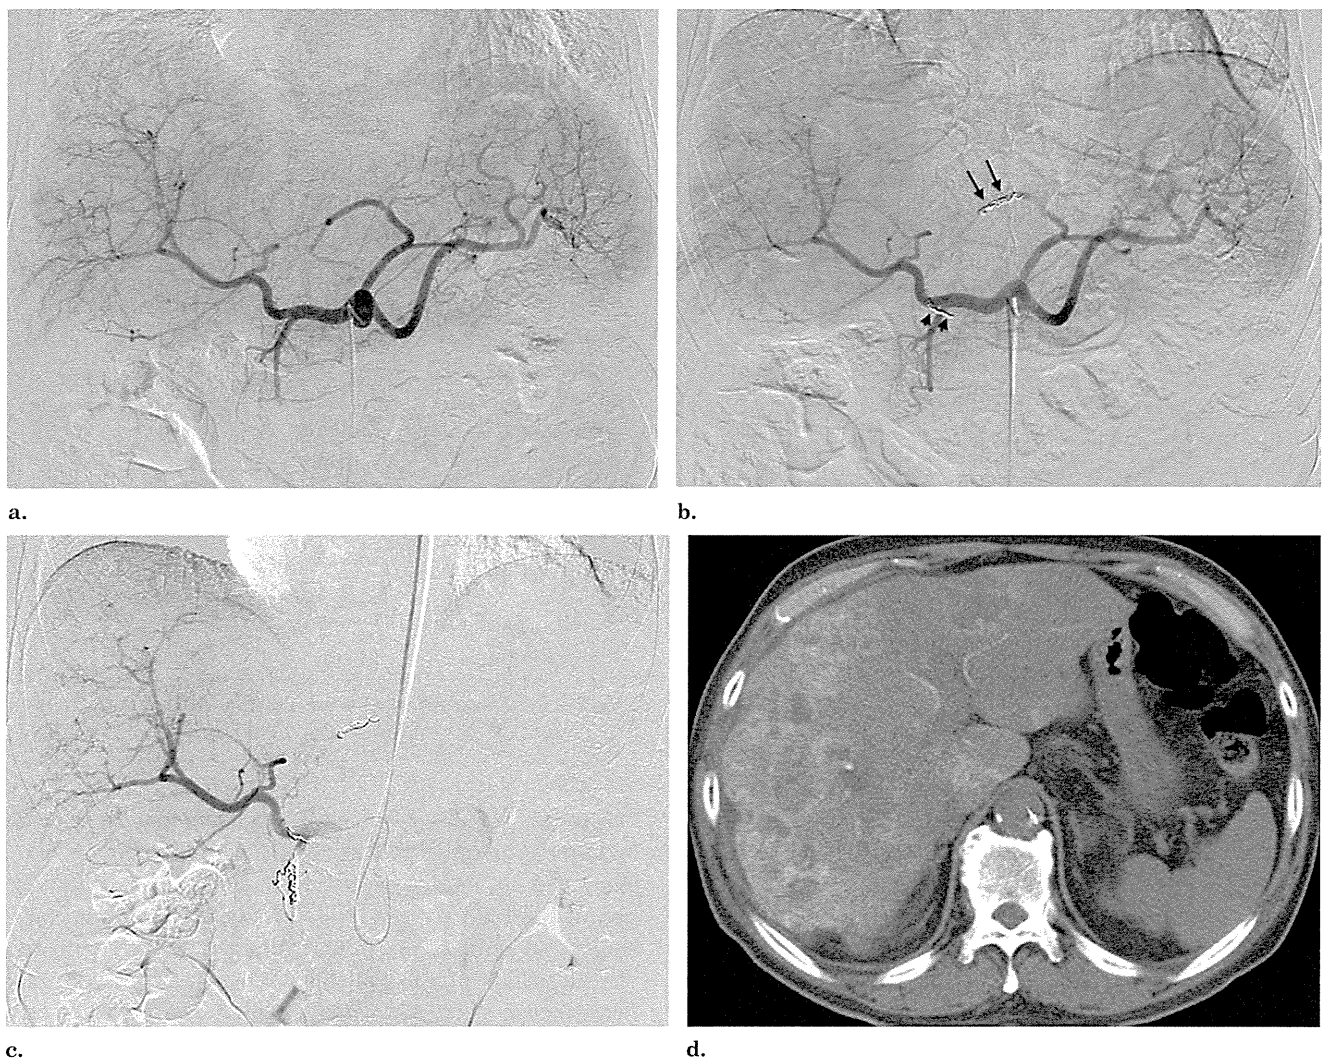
Image-guided insertion of catheter and port system for HAIC. (a) DSA of the celiac artery. The left hepatic artery is arising from left gastric artery (ie, replaced left hepatic artery). (b) DSA after embolization of the replaced left hepatic artery (long arrows) and right gastric artery (short arrows). The left hepatic artery is visualized from the collateral vessels. (c) DSA via the implanted port. The indwelling catheter is implanted via the left subclavian artery. (d) CT angiography via the implanted port. Adequate drug distribution is confirmed with enhancement of hepatic metastases by contrast material injected through the implanted port.
